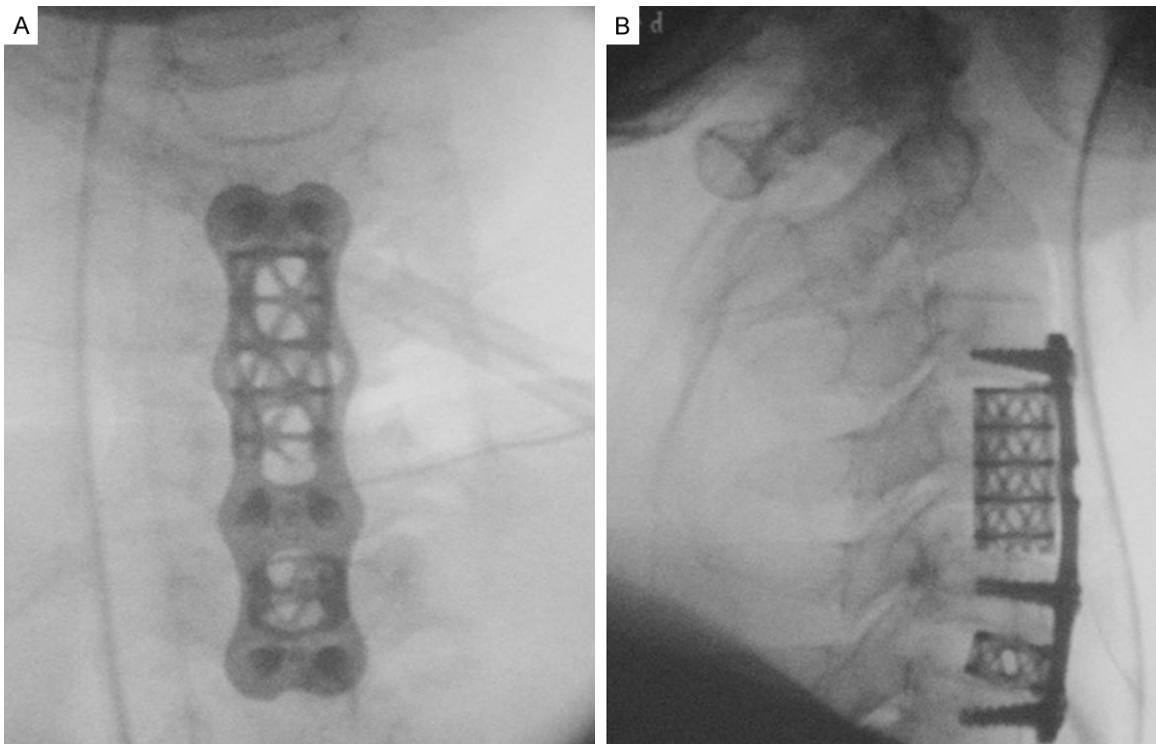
After anterior cervical C4 subtotal resection, C5-6 discectomy, titanium mesh and autogenous bone graft fusion, and C3-6 anterior plate internal fixation were performed, frontal and lateral X-ray radiographs of the cervical vertebrae were immediately taken.
